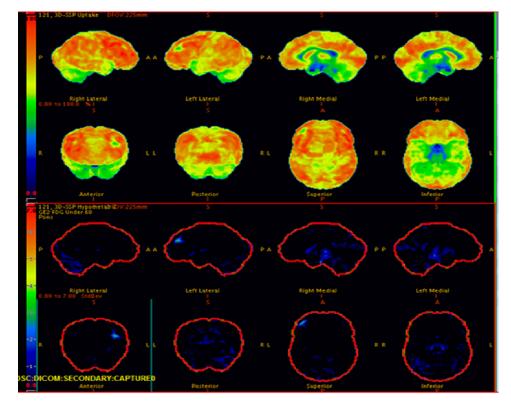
F-18 FDG-PET/CT showing a small area of decreased metabolism in the left anterior frontal lobe, corresponding in location to the abnormality seen on previous ictal brain perfusion scan, and represents the epileptic focus. CT, computed tomography; FDG, fluorodeoxyglucose. (Color version of figure is available online.)
